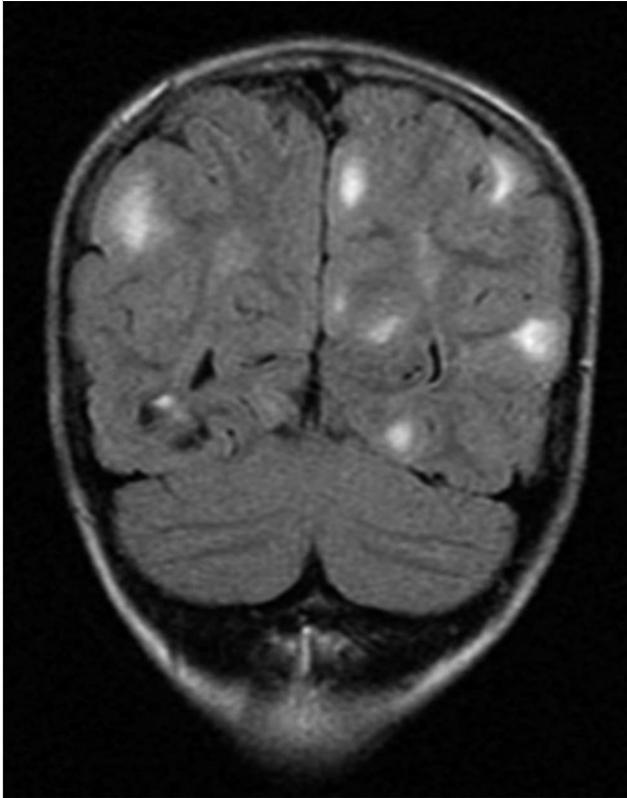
Magnetic resonance (MR) imaging of the brain of a 4-year-old girl with tuberous sclerosis complex. This coronal fluid-attenuated inversion recovery (FLAIR) sequence demonstrates tubers, which represent focal areas of cortical dysplasia and appear as expanded gyri with high intensity on all MR imaging sequences. Tubers do not generally enhance with contrast.
